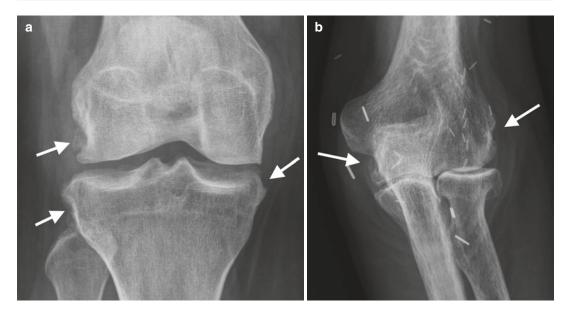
(a) AP radiograph of the knee in a 24-year-old female patient with long-standing RA with multifocal erosions (*arrows*) with sclerotic margins suggesting erosions
